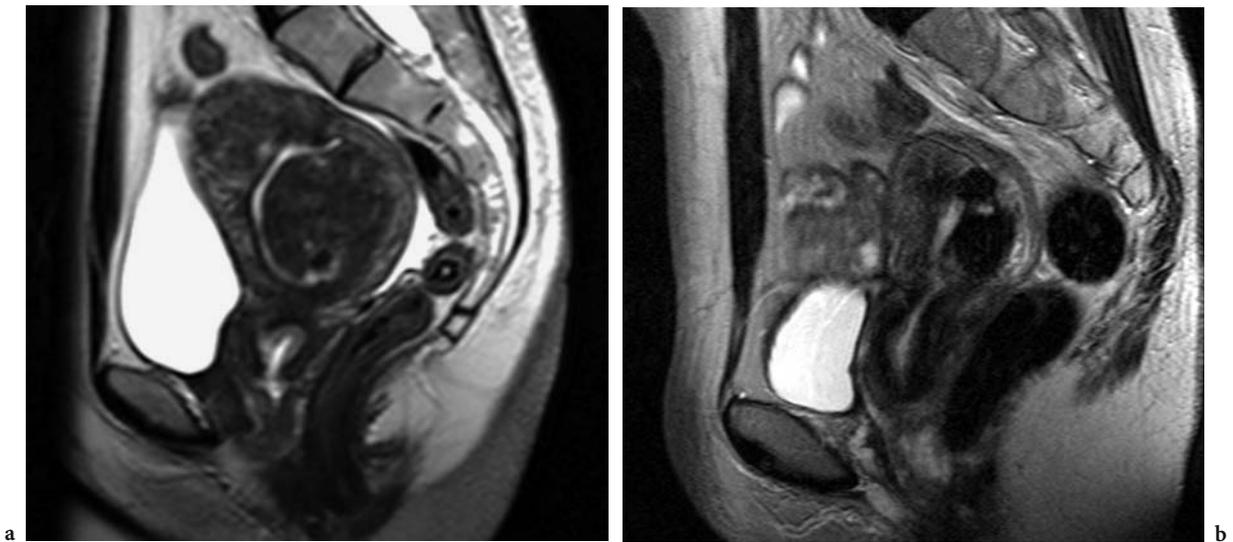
Sloughing of uterine fibroids after UAE. a Sagittal T2-weighted prior to UAE shows an intramural leiomyoma in the fundus and a submucosal leiomyoma in the posterior uterine wall. b Sagittal T2-weighted 24 months after UAE. While the patient reported marked improvement of leiomyoma-associated menorrhagia as early as 3 months after UAE, a late follow-up MRI shows marked decrease in size of the leiomyoma due to ongoing fibroid sloughing
